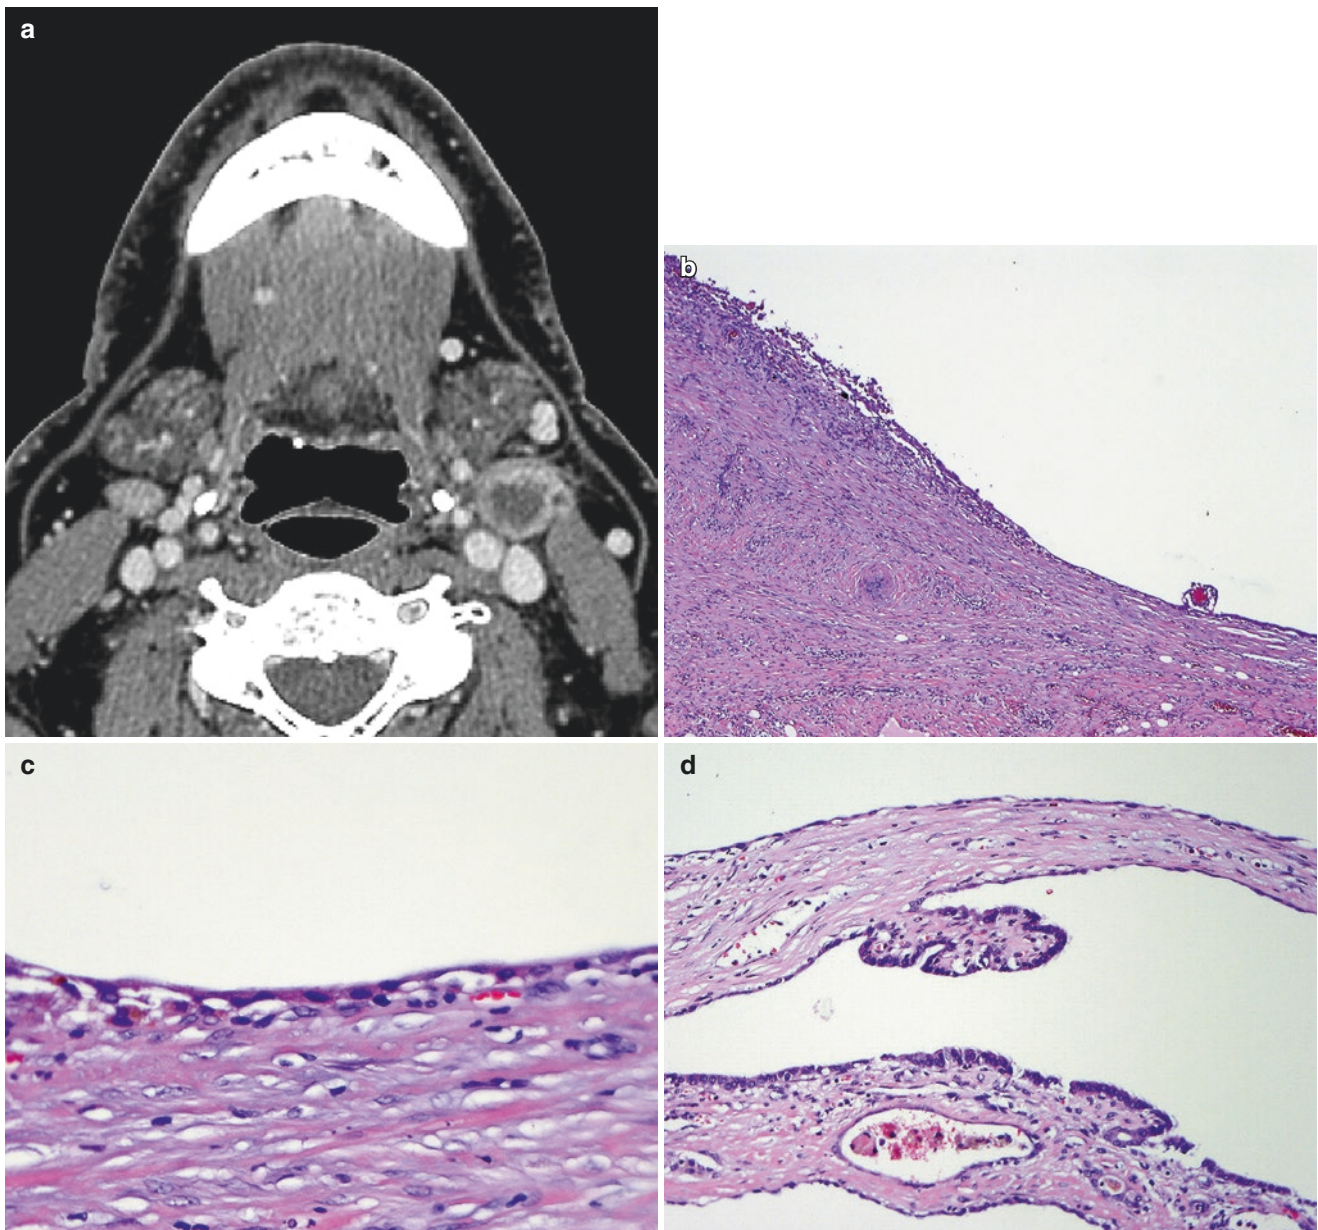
Case 1. (a) A CT scan shows a cystic mass in the left lateral neck. (b) The cyst wall is fibrotic with (c) an attenuated lining. (d) Focal areas show papillae lined by atypical, elongated nuclei with fine chromatin and nuclear overlap
